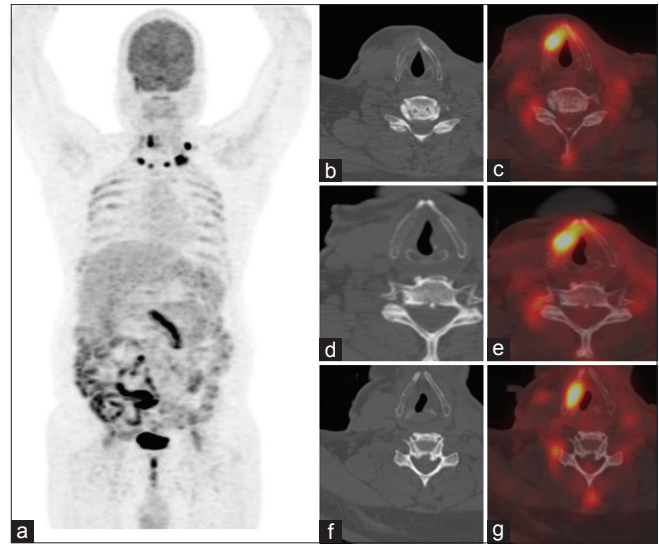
(a) Maximum intensity projection image of F-18 fluorodeoxyglucose positron emission tomography-computed tomography showing multiple focal increased areas of fluorodeoxyglucose uptake in the neck region. (b, d and f) Represents axial computed tomography image showing lytic lesions in the right lamina of thyroid cartilage showing increased fluorodeoxyglucose uptake in the respective corresponding fused positron emission tomography-computed tomography images (c, e and g)
